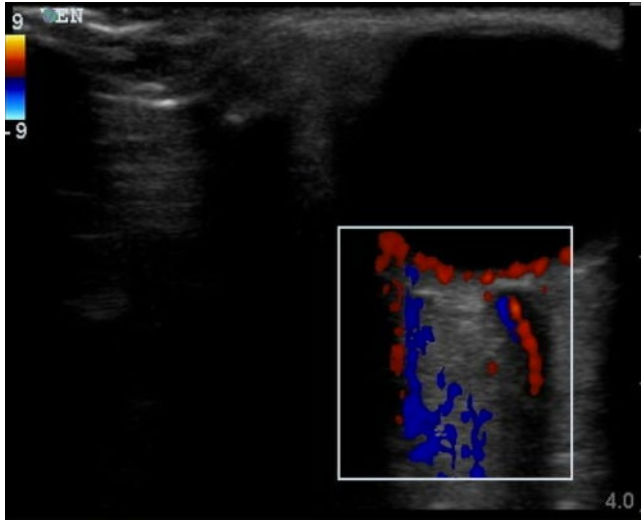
Colour Doppler imaging showing central retinal artery and vein within the optic nerve sheath and ciliary artery branches. Image courtesy of Beatrice Hoffmann, M.D.
